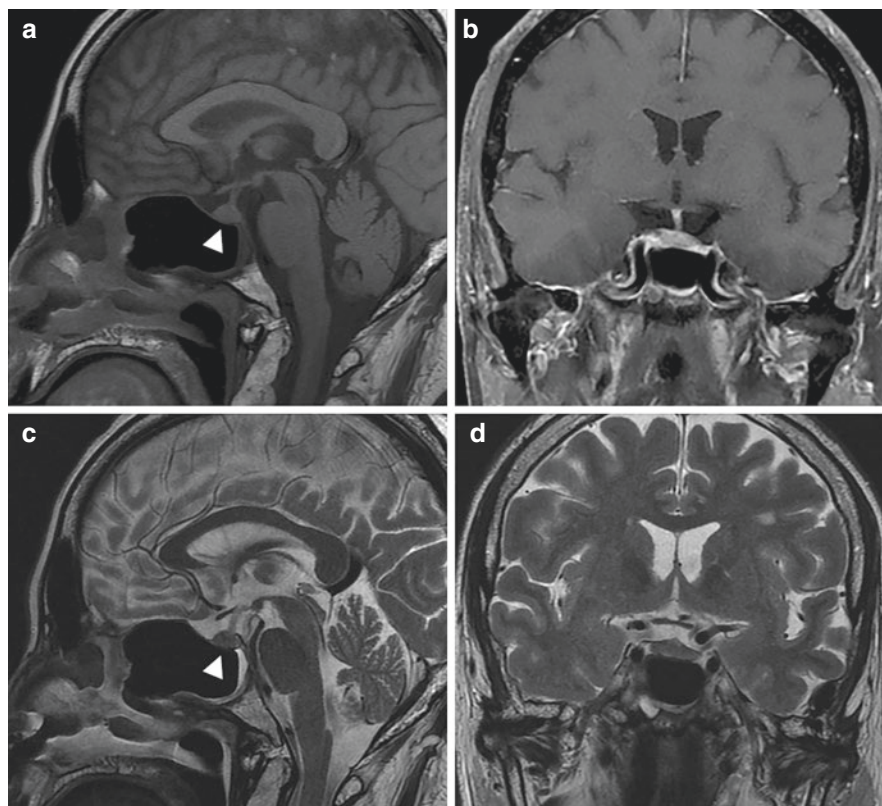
Isolated giant fungal mucocoele of the sphenoid sinus. Postoperative MRI images (a–d). Note the decompressed pituitary gland (a, c; arrowheads) and the decompressed optic chiasm in (d)
